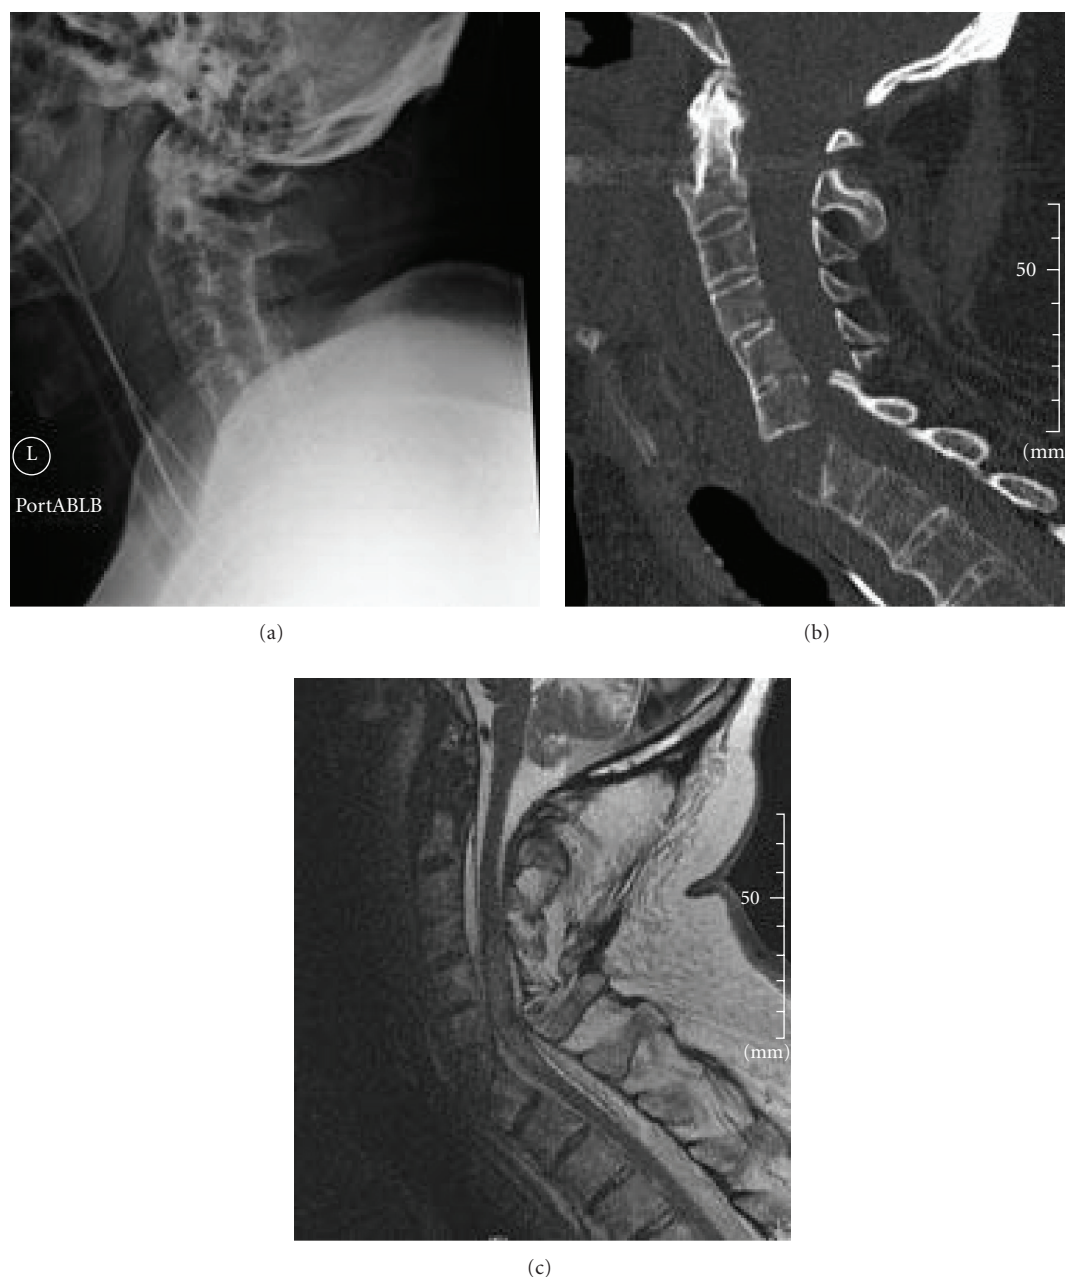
(a) Lateral C-spine X-ray providing an incomplete evaluation of the cervicothoracic junction and failing to delineate the fracture due to high-riding shoulders and kyphotic deformity. (b) Sagittal reconstruction of the computed tomographic scan of a 75-year-old male with a displaced extension-type fracture through the subaxial cervical spine. (c) Sagittal magnetic resonance image of the same patient demonstrating compression and edema of the spinal cord due to the displaced fracture.
